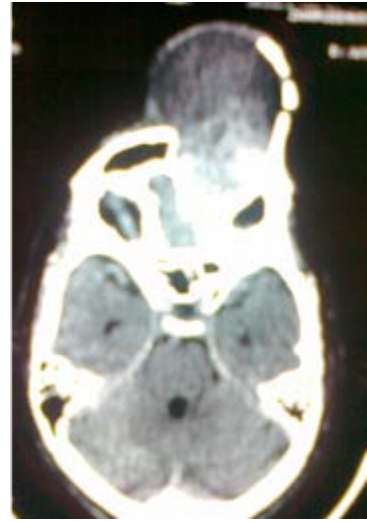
CT scan axial section of giant left frontal mucocele
